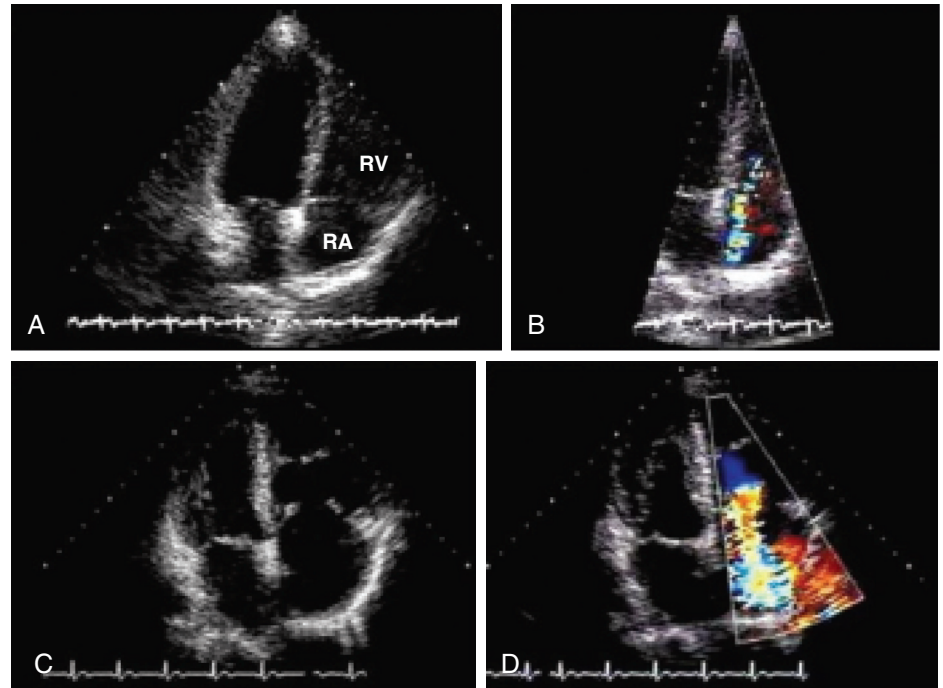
TR caused by carcinoid involvement of the tricuspid valve. Serial two-dimensional echocardiograms (A and C) and color Doppler studies (B and D), separated by 3 years are shown. C. After 3 years, severe thickening and fixation of the tricuspid leaflets are evident, with consequent severe TR and associated RV and right atrial (RA) enlargement. (From Møller JE, Connolly HM, Rubin J, et al: Factors associated with progression of carcinoid heart disease. *N Engl J Med* 348:1005, 2003.)
